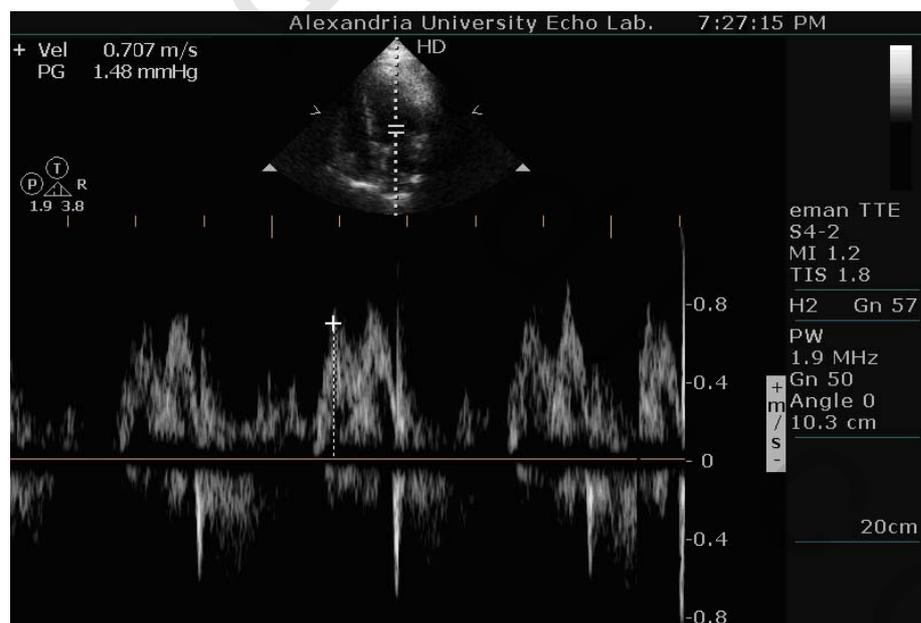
Mitral inflow by pw Doppler after dialysis.
